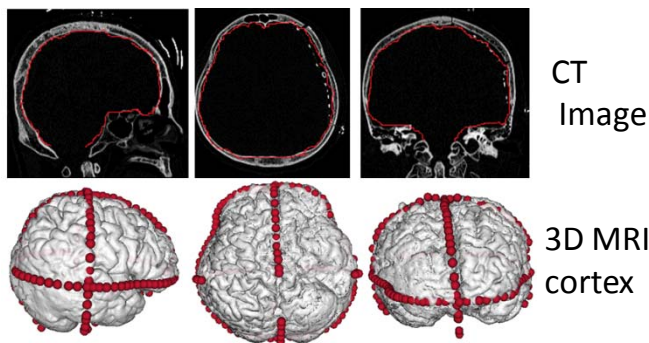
Inner contour of skull (the red point in the CT image showing as red ball in 3D MRI cortex with co-register coordinates)
